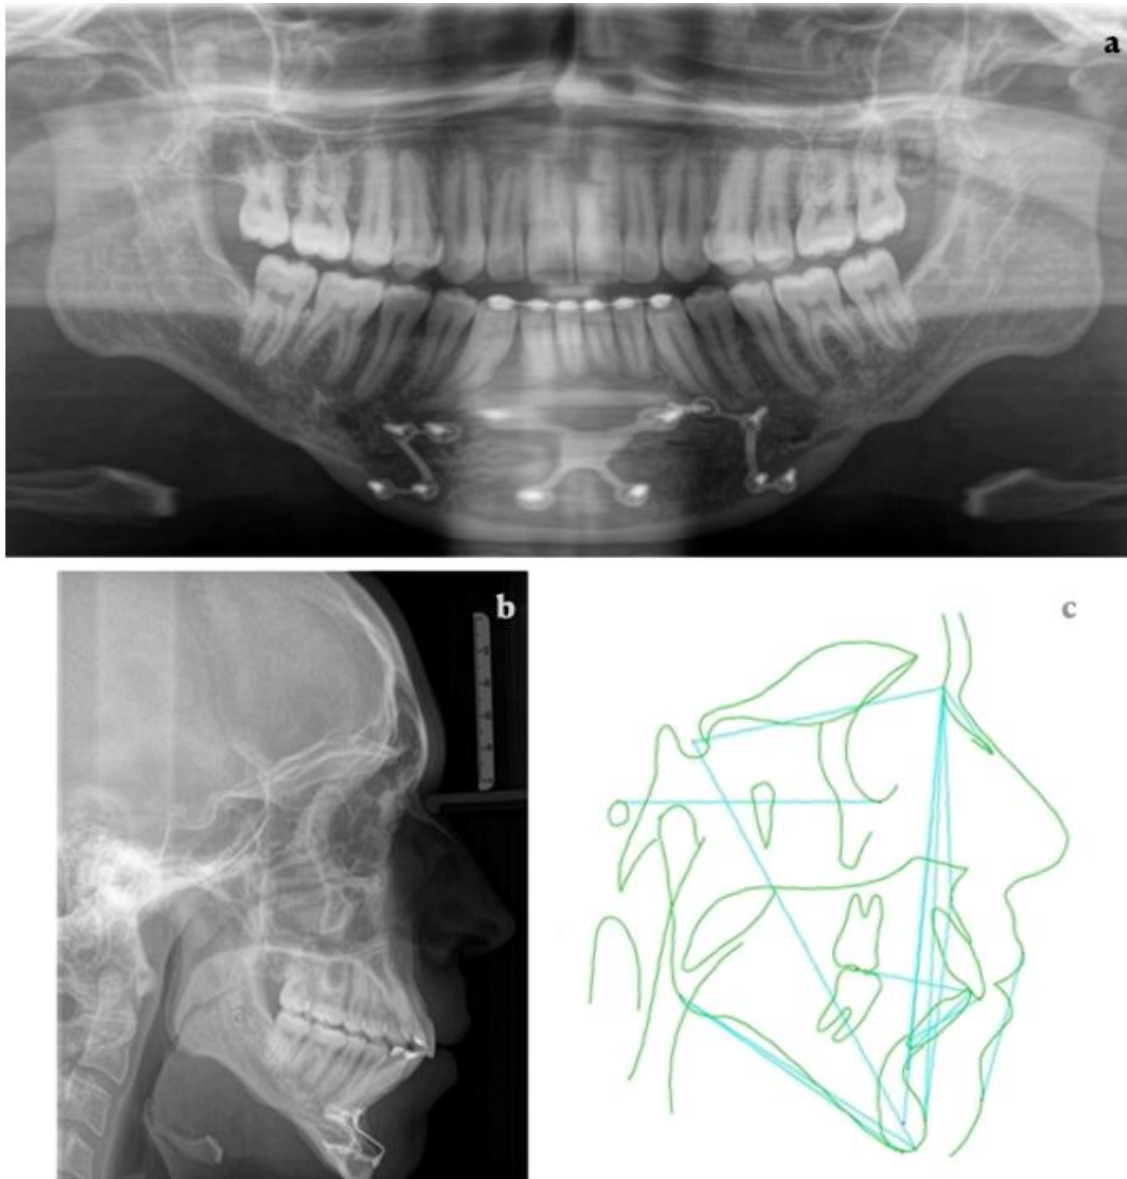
a: Final panoramic radiograph; b: Final lateral cephalometric radiograph; c: Final cephalometric tracing.
